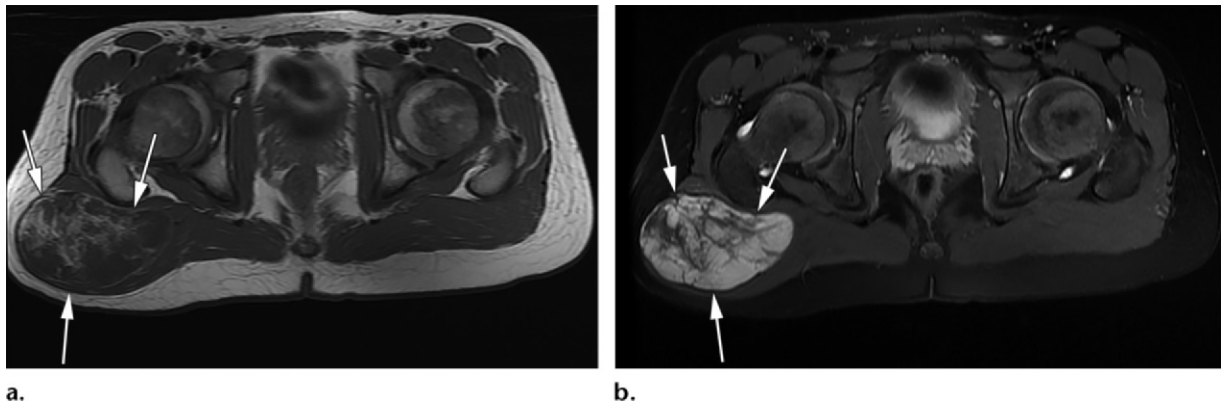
Lipoblastoma in a 13-year-old boy with a painless right gluteal mass. (a) Axial T1-weighted MR image shows a heterogeneous, well-circumscribed mass (arrows) in the right gluteus maximus muscle. Patchy and wispy areas of hyperintense signal within the mass suggest the presence of fat; however, the hyperintense signal is less intense than that of normal subcutaneous fat. (b) Axial fat-saturated proton density-weighted MR image shows markedly hyperintense signal within the mass (arrows), likely reflective of myxoid stroma. Surgical excision and pathologic evaluation allowed confirmation of a lipoblastoma.
